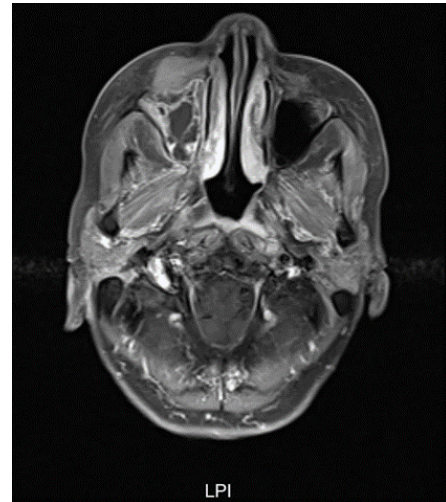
MR image showed maxillary sinuses anterior wall recurrence with a soft tissue mass in the anterior wall of the right maxillary sinus and bony destruction.
